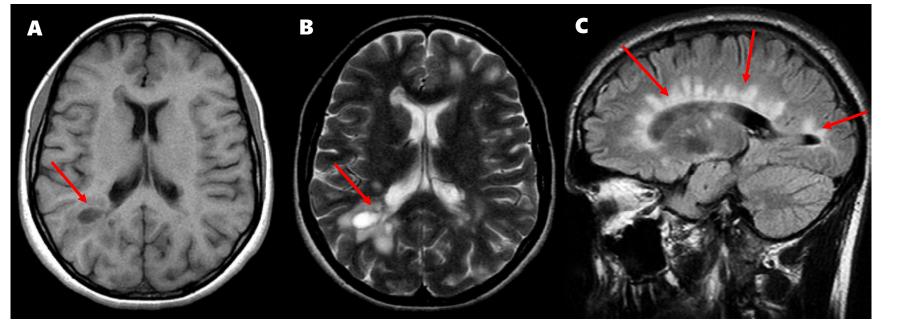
Multiple sclerosis with characteristic periventricular white matter ovoid lesions perpendicular to the ventricles (arrows). The lesions are isointense on T1-weighted (A), hyperintense on T2-weighted (B) and on FLAIR (C) images.
